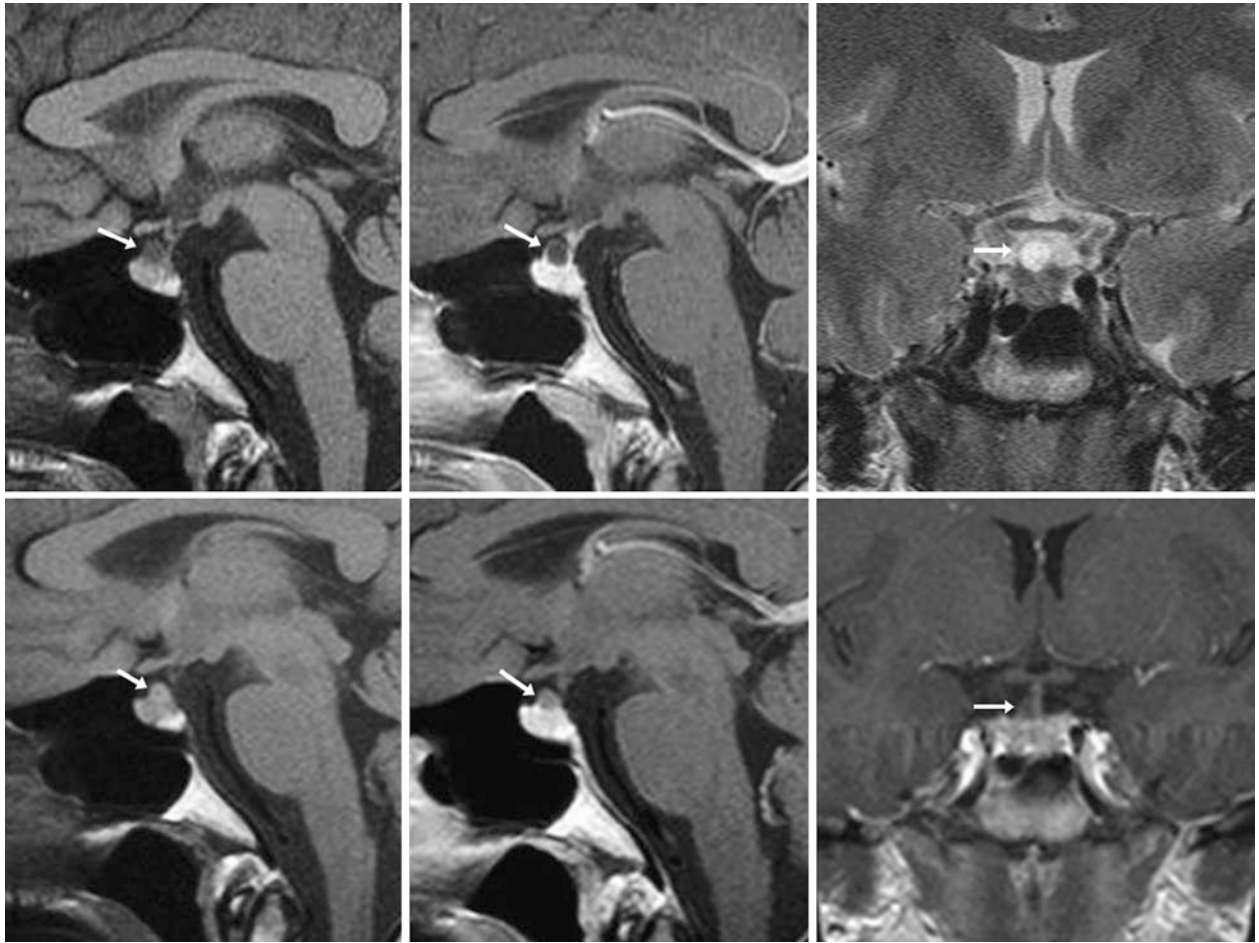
The patient was a 27-year-old female without pituitary symptoms. A 1.5 T MRI delineated a small, 5-mm pars intermedia cyst (RCC) within the anterior pituitary (arrows) that was hypointense on both noncontrast sagittal T1WI (top left) and postcontrast sagittal T1WI (top middle), with signal intensity similar to that of CSF on T2WI (top
